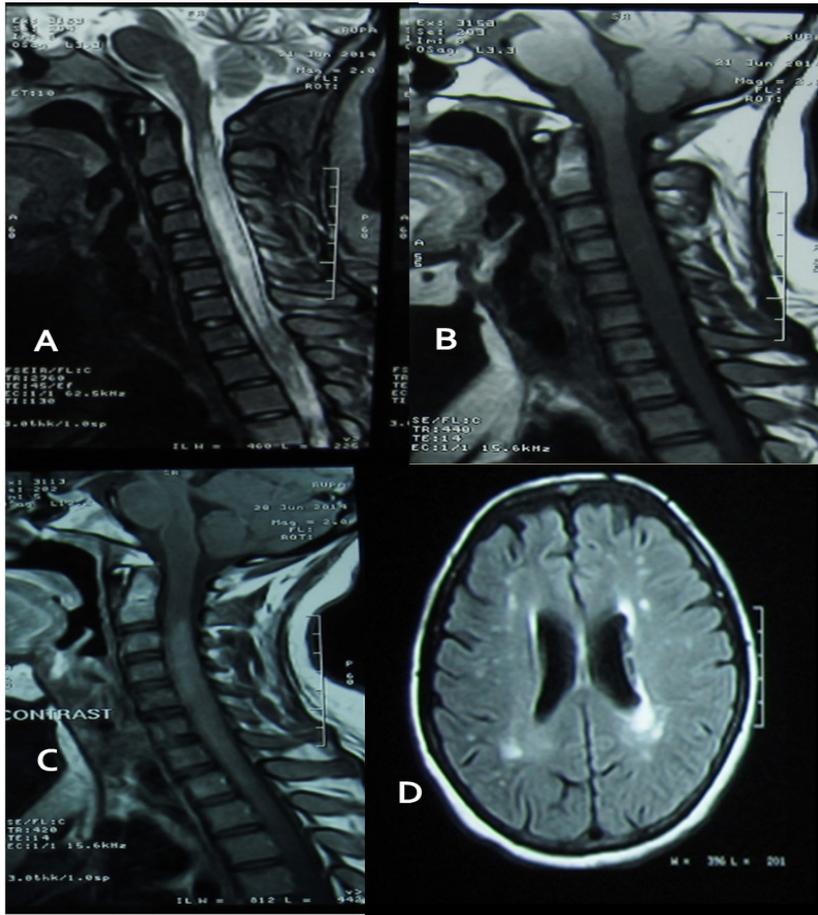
A. T2 sagittal image showing long segment hyperintense lesion; B. T1 image showing hypointense lesion with enlargement of the cord; C. Gd enhancement of the cord lesion; D. FLAIR axial section of MRI brain showing multiple white matter lesions.
